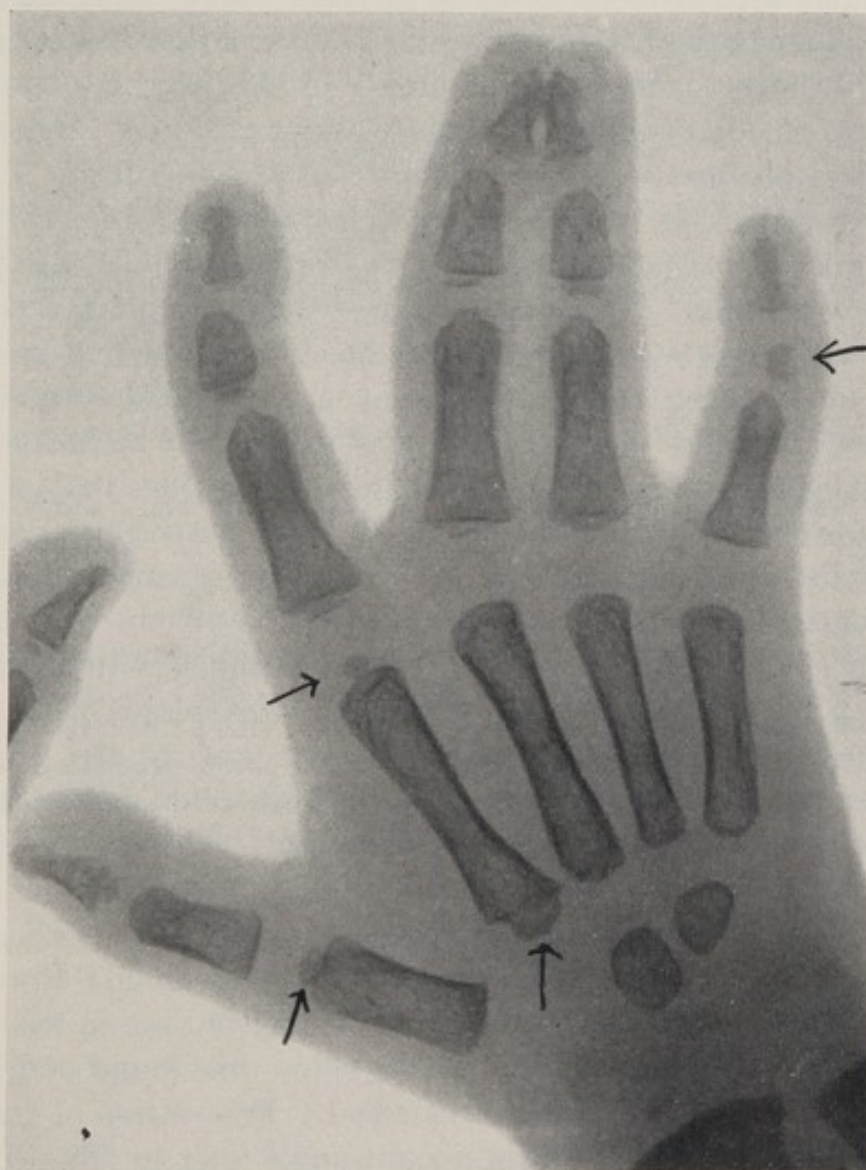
X-ray of hand of a mongoloid child 3 yrs. of age. Most outstanding is the syndactyly, which is, however, not too frequent in mongolism. The x-ray shows several peculiarities which are frequently found in mongolism. Note the distal epiphysis on the first phalanx of the thumb and a proximal epiphysis on the first phalanx of the index finger. Note the rudimentary middle phalanx of the little finger and general shortness and delicacy of bones. Note the deficiency of calcification. Only two metacarpal bones are present and the epiphysis of radius is missing. Bone age 6 months.
